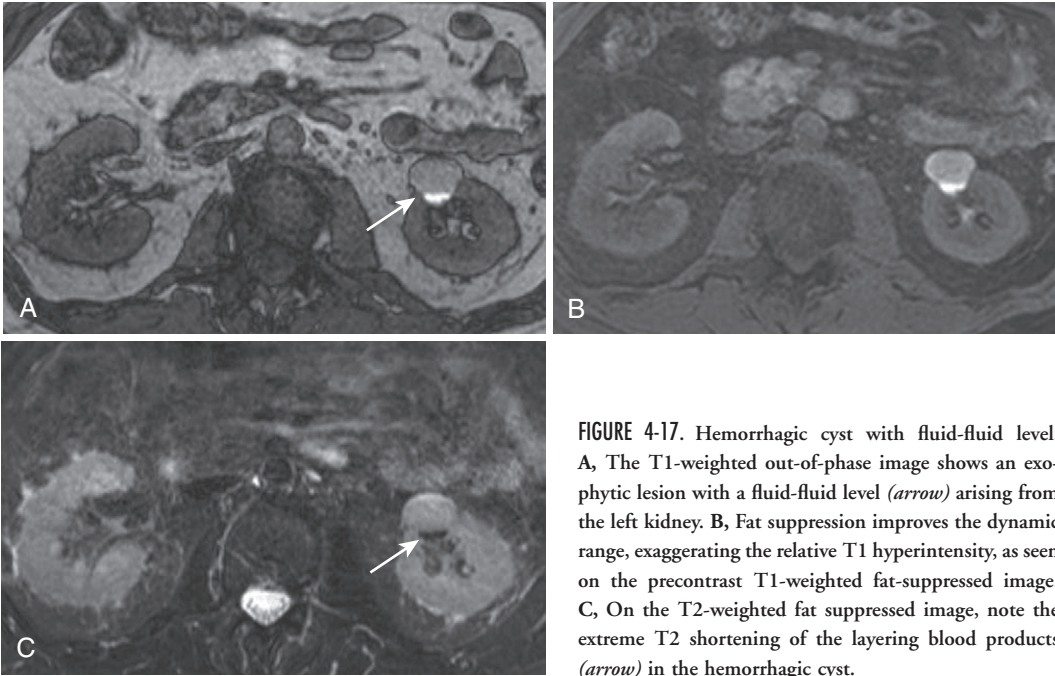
Hemorrhagic cyst with fluid-fluid level. A, The T1-weighted out-of-phase image shows an exophytic lesion with a fluid-fluid level (*arrow*) arising from the left kidney. B, Fat suppression improves the dynamic range, exaggerating the relative T1 hyperintensity, as seen on the precontrast T1-weighted fat-suppressed image. C, On the T2-weighted fat suppressed image, note the extreme T2 shortening of the layering blood products (*arrow*) in the hemorrhagic cyst.
